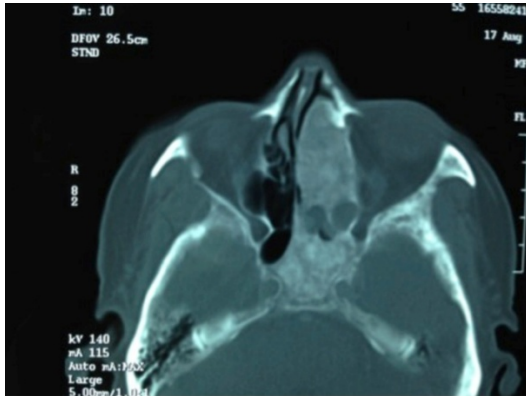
Axial slice view by computed tomography
